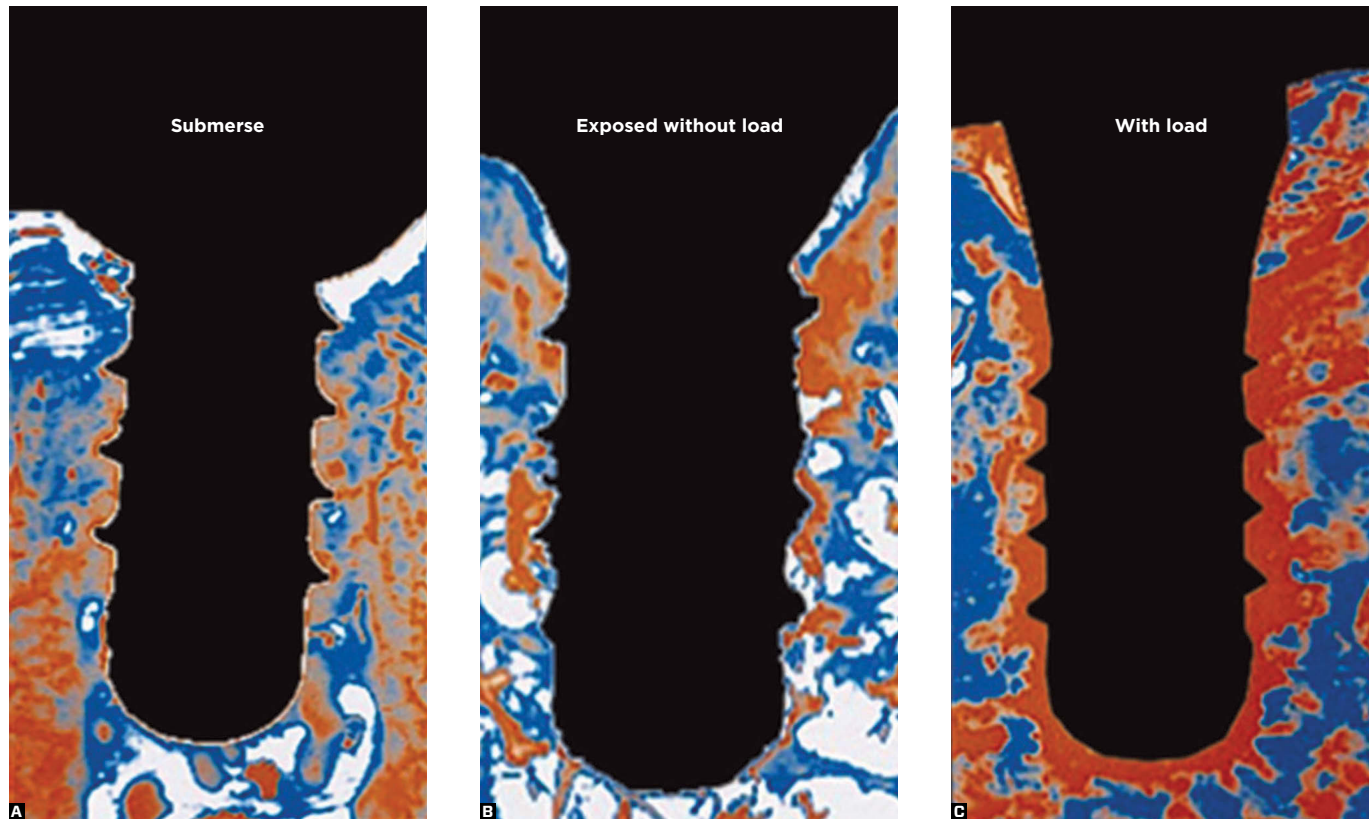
In these images from Akin-Nergiz et al,¹ the radiographic densitometry in bone areas that received osseointegrated implants reveal differences when they are not subjected to load, for being submerge (A); when exposed, but with no masticatory load (B); and when exposed and subjected to occlusal loads (C). Bone density increases significantly (red areas) when osseointegrated implants receive masticatory load if compared to the original alveolar cancellous bone, in blue.
